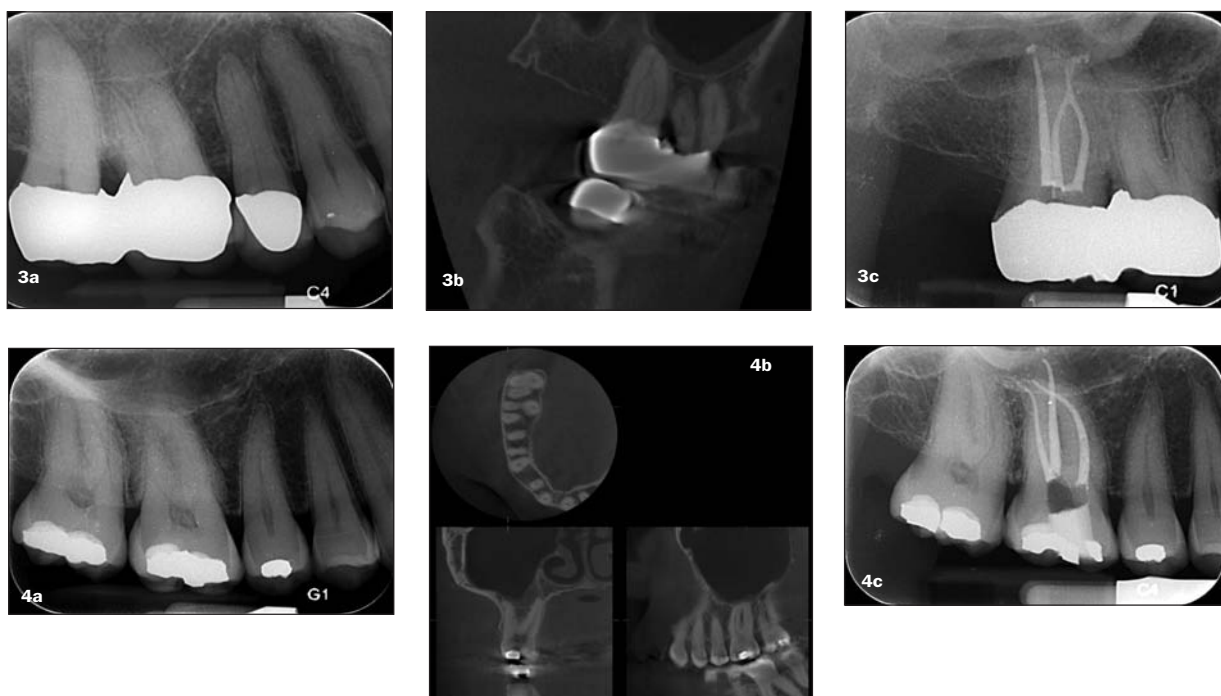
The patient was CT scanned, revealing a large periapical lesion
